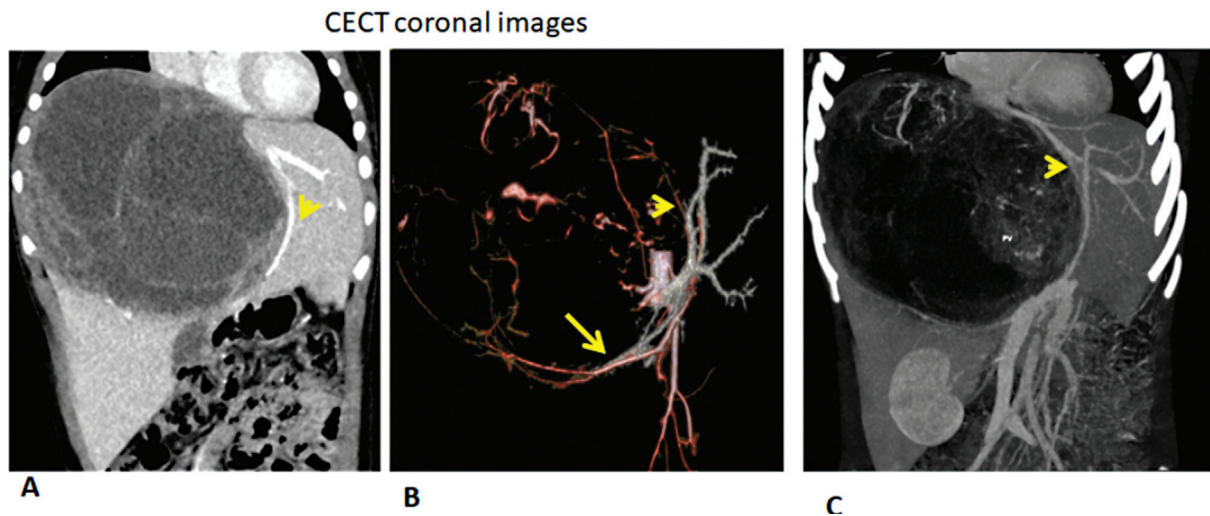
(A) Contrast-enhanced computed tomography (CECT) coronal images showing predominantly cystic tumor displacing the middle hepatic vein (arrowhead). (B) Volume rendered image showing displacement of hepatic artery (arrow) and portal vein (arrowhead) around the lesion. (C) Coronal oblique multiplanar reconstruction (MPR) images showing tumor displacing portal vein radicles (arrowhead).
